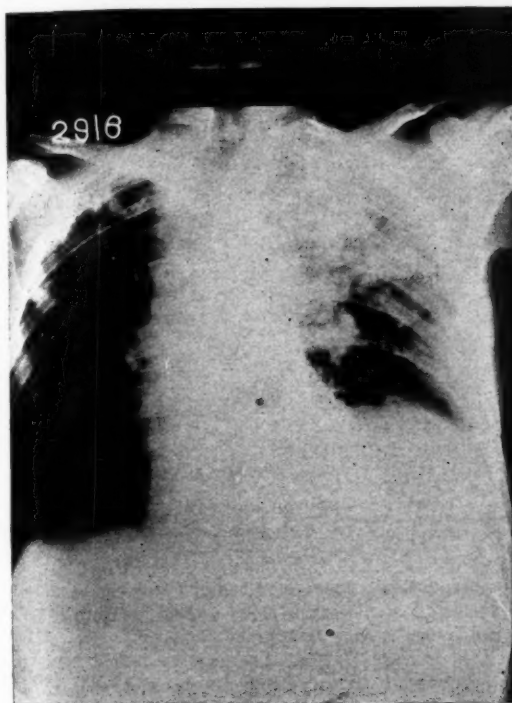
X-ray plate (Case 1) showing the existing pulmonary lesion.
